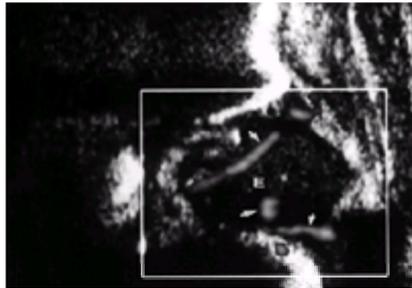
Power Doppler sonography of the normal hip. In this coronal view, there is clear depiction of flow in the vascular canals (arrows) of the proximal femoral epiphysis (E).
